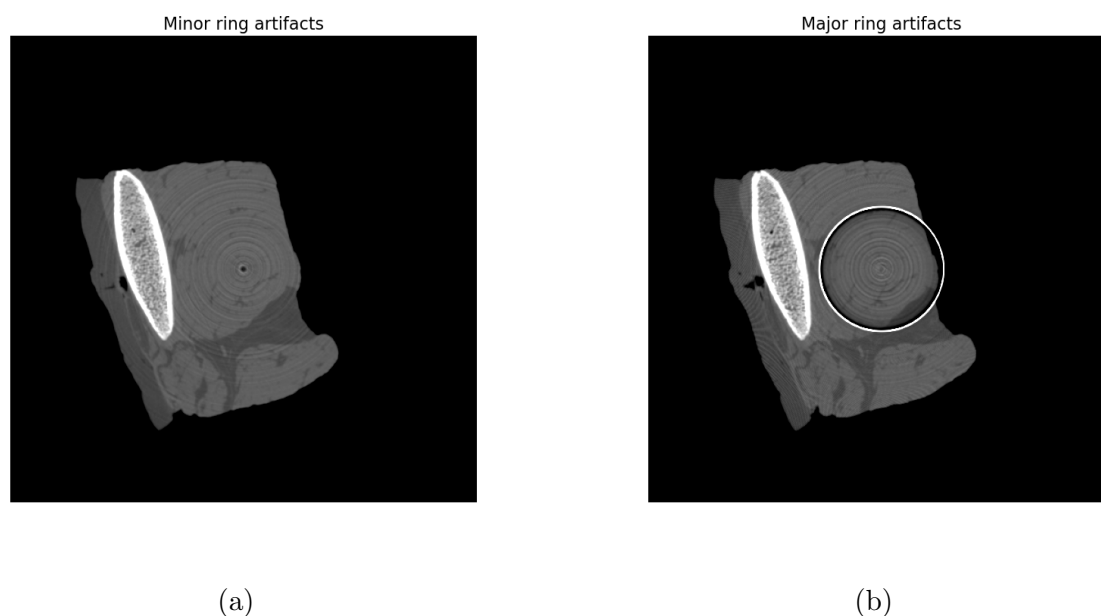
Ring Artifacts. CT slice of an *ex-vivo* tissue sample with (a) several minor ring artifacts and (b) a major ring artifact.
